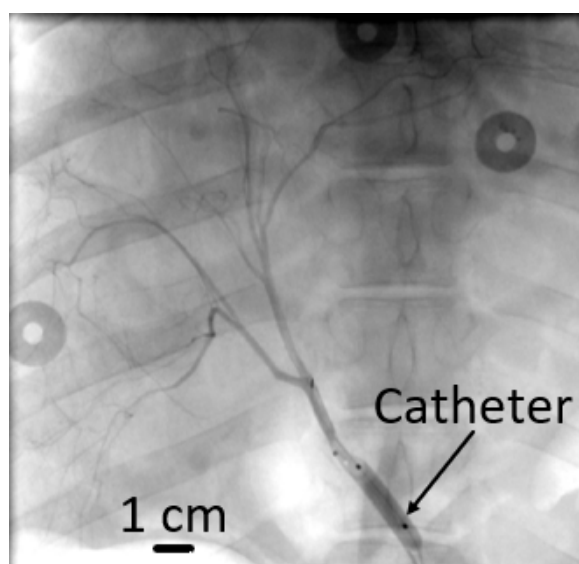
Figure B-2: CT image showing the catheter tip in the proximal hepatic artery.
